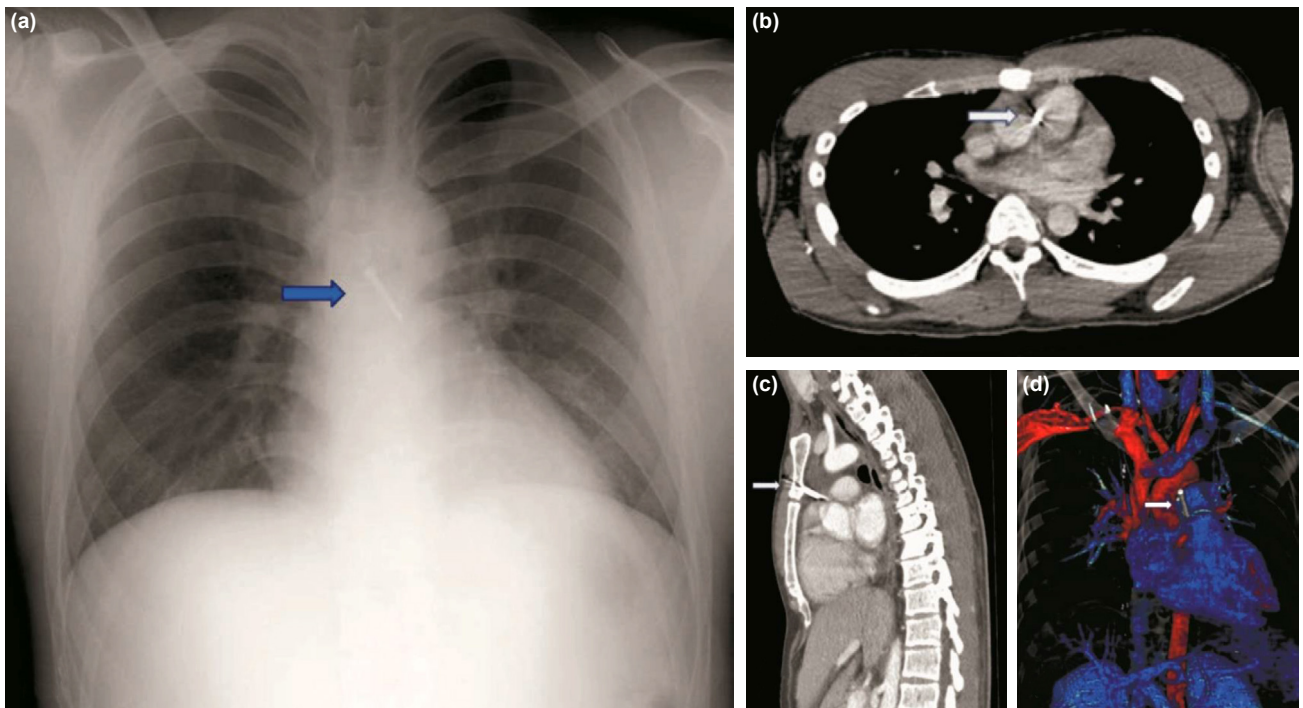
(a) Chest radiograph taken on admission. The chest radiograph reveals a cardiothoracic ratio of 52%, no mediastinal enlargement or pleural effusion, and no other obvious lung lesions. An opaque shadow of a foreign body is observed in the sternum and in the area overlapping the cardiac shadow (blue arrow). Axial (b), sagittal (c), and three-dimensional computed tomography (d) images obtained on admission show a rod-shaped nail penetrating the sternum from the precordial region to the anterior mediastinum. The nail tip is between the pulmonary artery and the aorta and is in contact with the main trunk of the pulmonary artery. Mediastinal hematoma and cardiac tamponade are not identified (white arrows).
